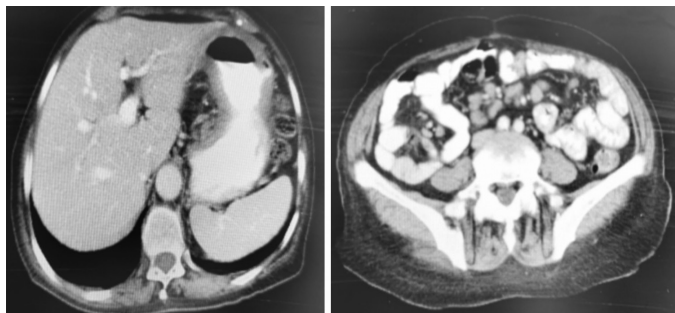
(A) Abdominal CT imaging diffuse gastric wall thickening (B) Multiple lymphadenopathy in mesentery
